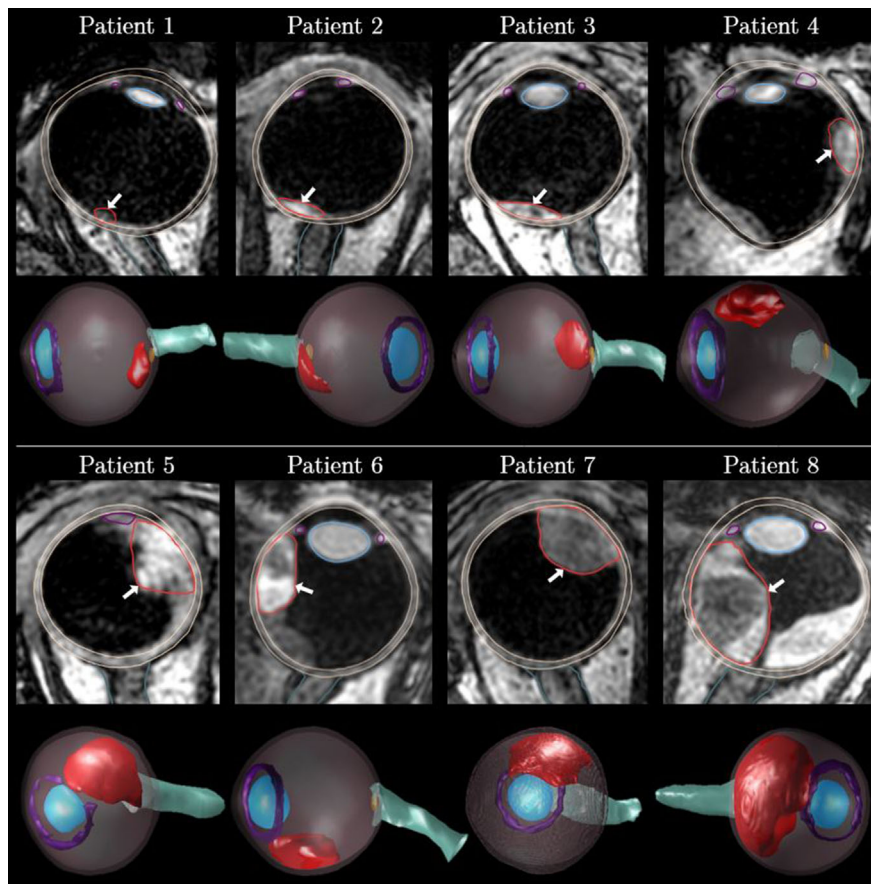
Patient cohort. Three-dimensional (3D) T1-weighted magnetic resonance (MR)-slices and reconstructed eyes with segmented MR contours: lens (blue); ciliary body (purple); optic nerve (green); sclera ring (beige); tumor (red). The white arrows indicate the uveal melanoma. Note that the macula (orange) is ellipsoidal-like shaped and only visible through the 3D-reconstructed MR-eyes, temporal side to the optic nerve head.
